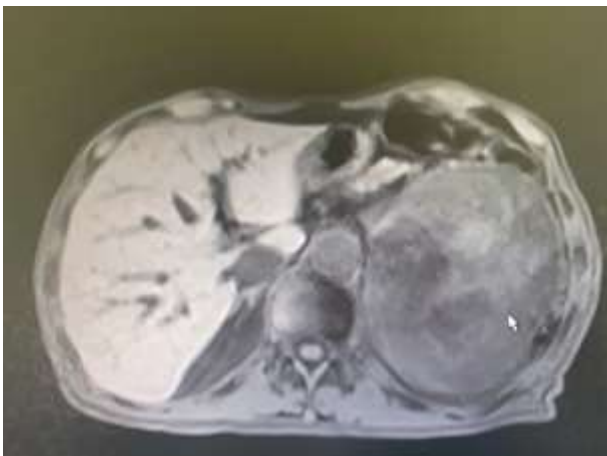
MRI Image of left- sided retroperitoneal sarcoma.
